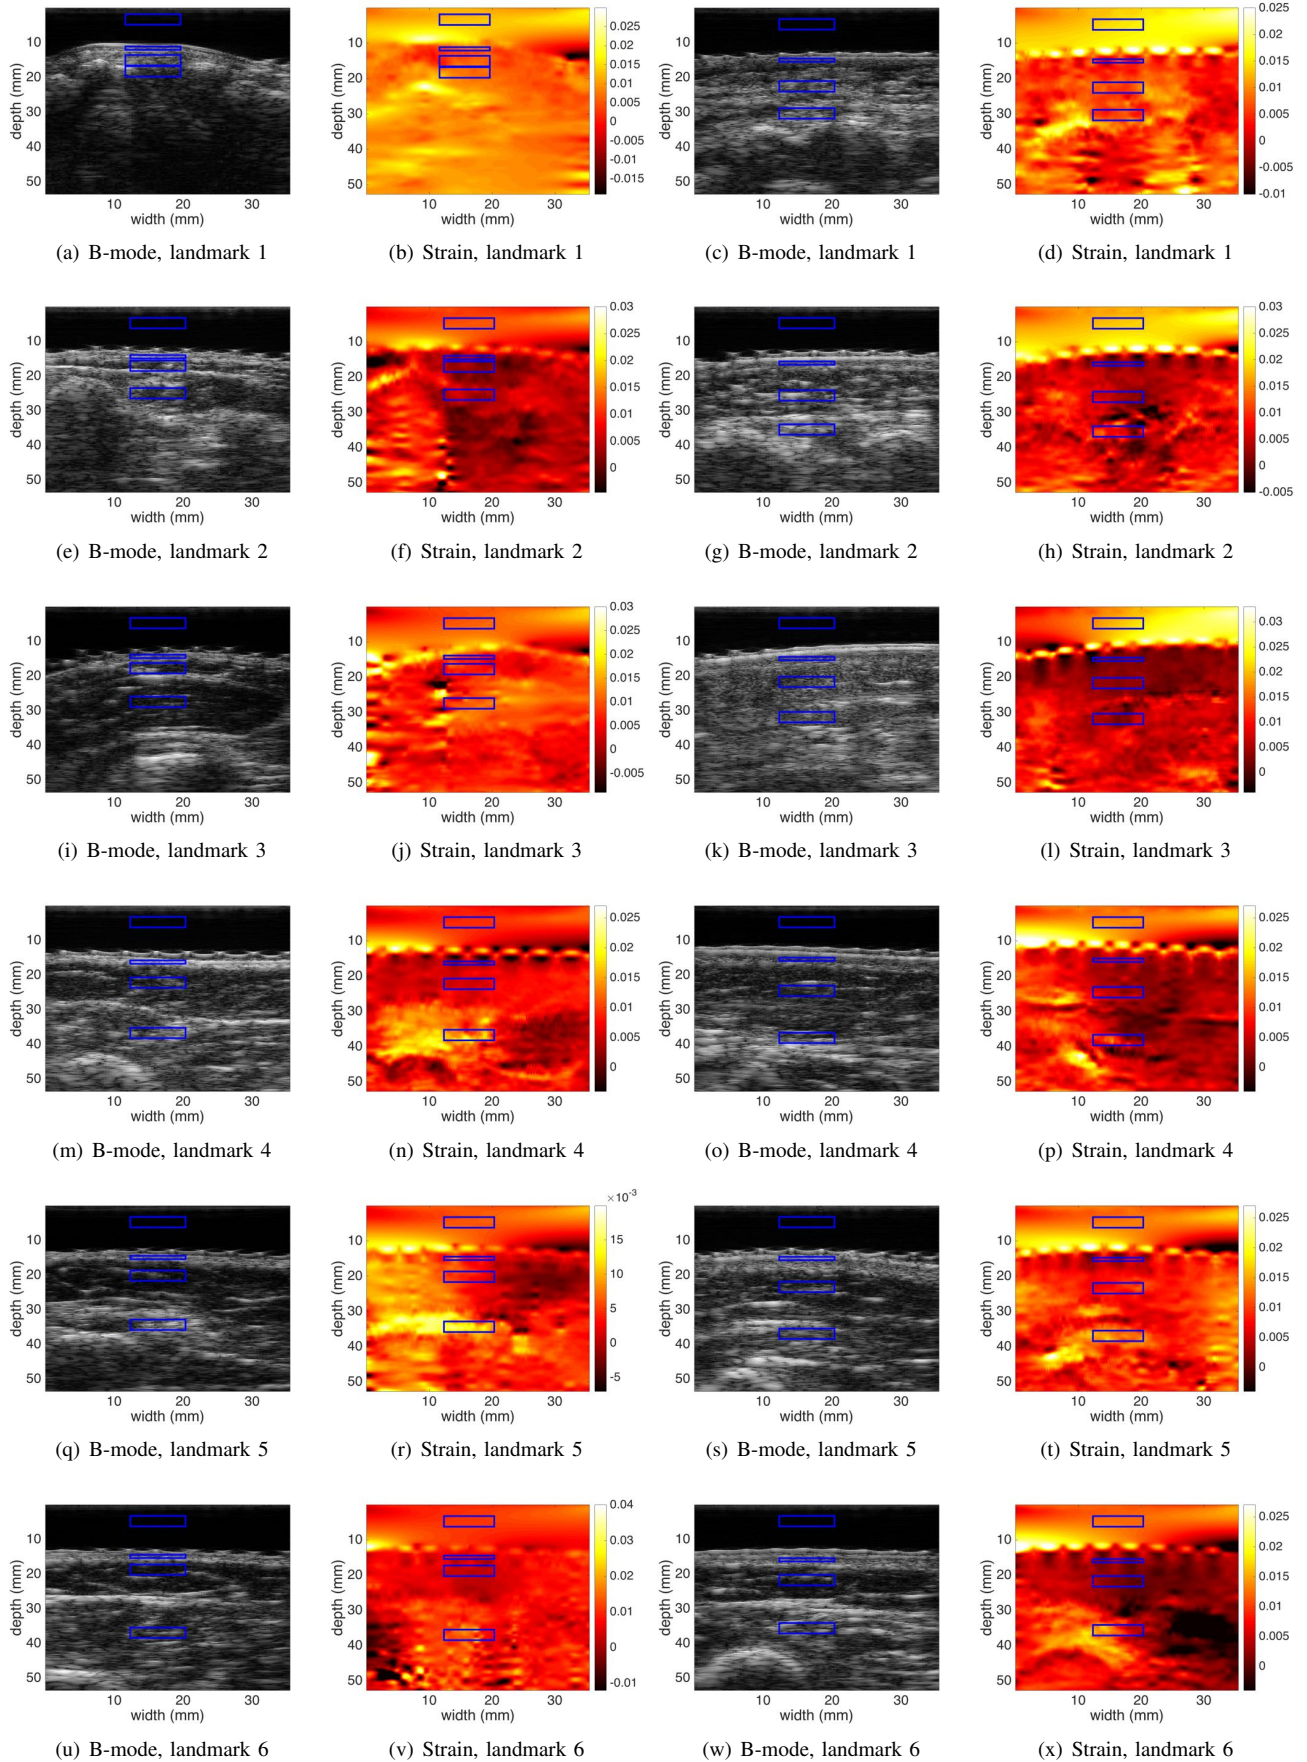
Ultrasound and strain images of the 6 landmarks shown in Figure 4 in the unaffected arm (first and second columns) and affected arm (third and fourth columns).
